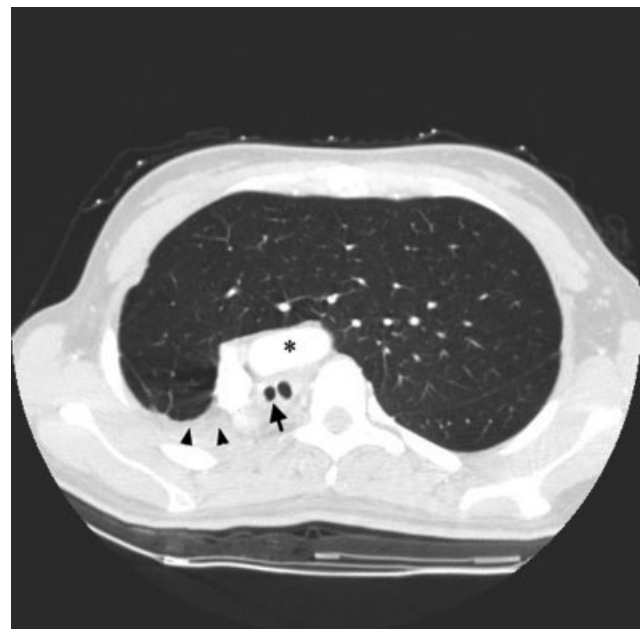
Chest CT, with an asterisk denoting the aortic arch; an arrow, the right main-stem bronchus, which would soon terminate; and arrowheads, the collapsed right lung.
